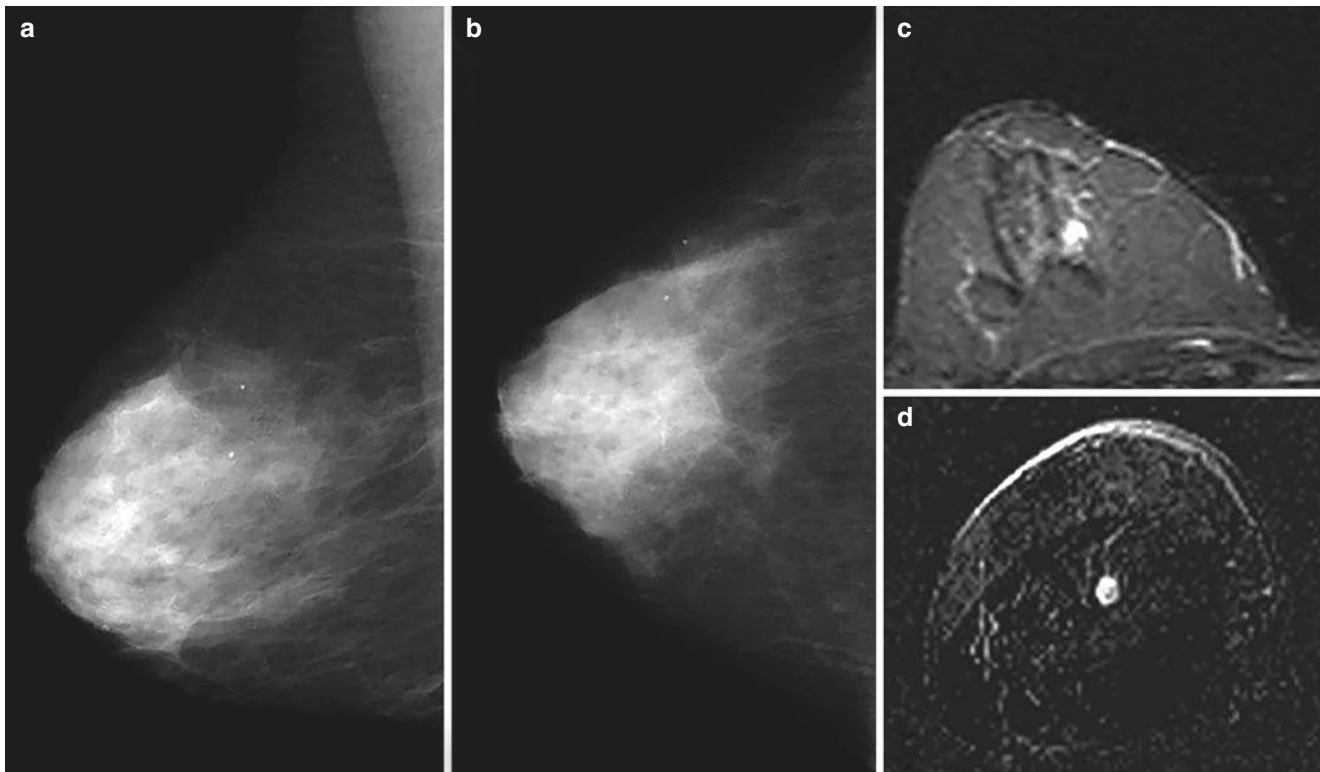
Case from the HIBCRIT study. A 53-year-old BRCA1 mutation carrier, already treated for an invasive ductal cancer of the left breast at 33 years of age, underwent multimodal screening including clinical breast examination (CBE), mammography, US, and MRI. The left breast only showed minimal signs of the previous treatment at each screening modality (not shown). Mammography of the right breast showed a negative dense breast (a) and (b). Also CBE and US (not
